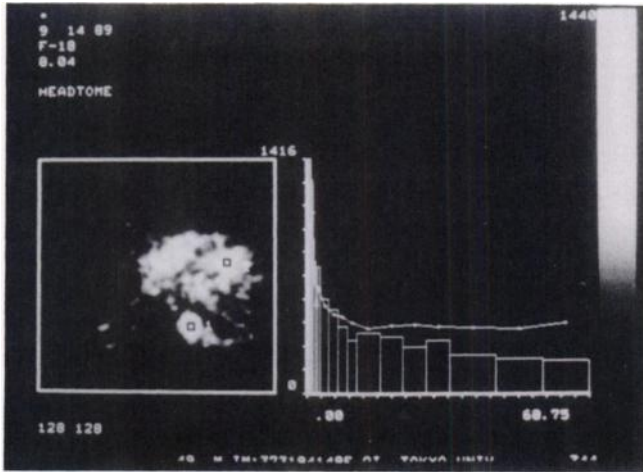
Left: Rectangular ROIs set on descending aorta and left ventricular blood pool of the same patient as in Figure 1. Left ventricular cavity is narrowed because of myocardial hypertrophy. Right: FDG time-activity curves obtained from these ROIs. At the later phase, the curve of the left ventricular blood pool is obviously elevated by spillover from myocardium. In this patient, the aortic cavity is large enough and the partial volume effect on the aortic curve is negligible.
